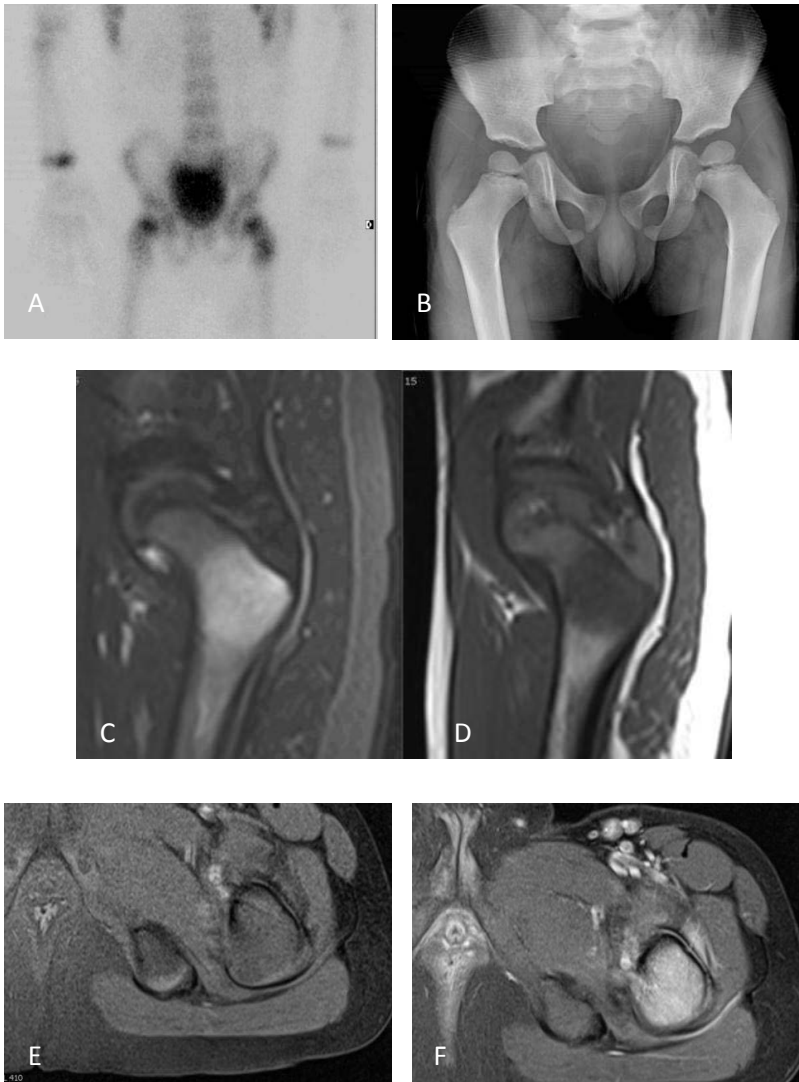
Nuclear medicine bone scan image (A) in a 4-year-old boy with bacteremia demonstrates mild focal radiopharmaceutical uptake in the left femoral intertrochanteric region. No radiographic abnormality is seen (B). STIR (C) and T1 (D) weighted images angled through the left femur demonstrate hyperintense T2 and hypointense T1 signal in the region. Axial T1 pre (E) and post-contrast (F) images show enhancement of this region.
